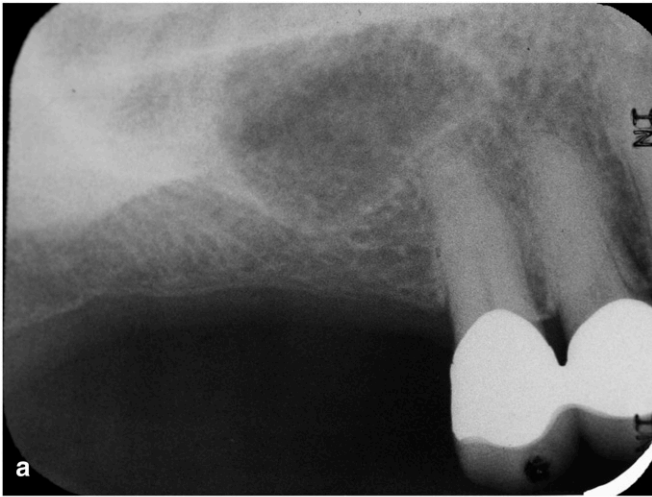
Clinical scenario 4. 14a Preoperative radiograph. Residual ridge height was insufficient for implant placement. 14b Sinus elevation was performed in a 65-year-old patient.
